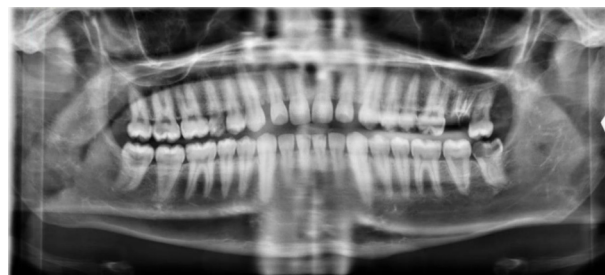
Initial orthopantomogram showing no bone changes in the left molar mandibular region. However, tooth 38 showed deep decay and periapical radiolucency.
